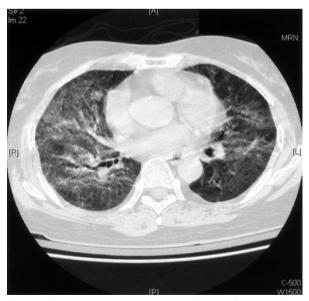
Computed tomography showed bilateral ground glass opacification.
